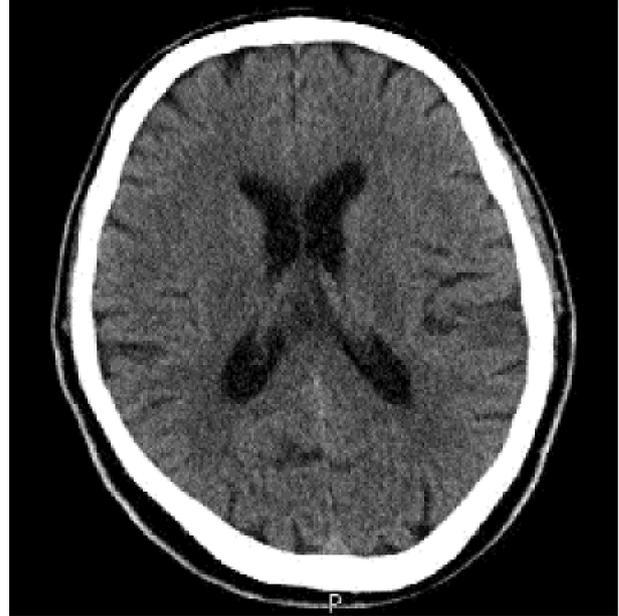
CT scan brain showing no abnormal findings.
